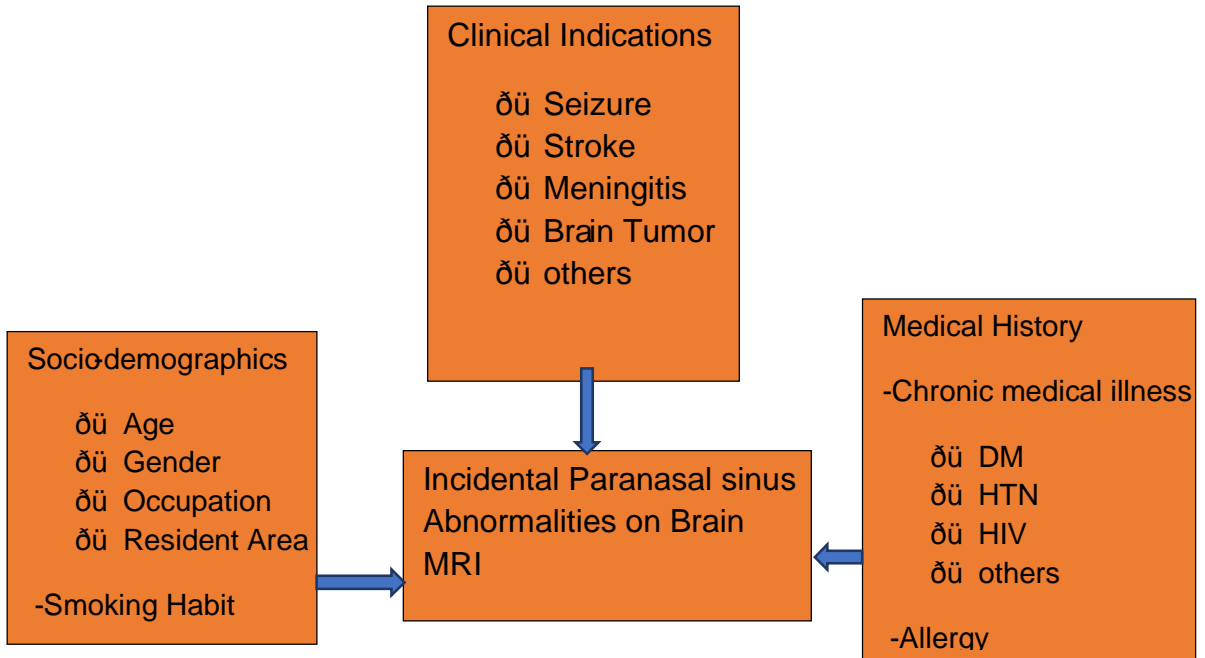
Conceptual framework for the magnitude of incidental finding of paranasal sinus abnormalities and its associated factors on Brain MRI study.
